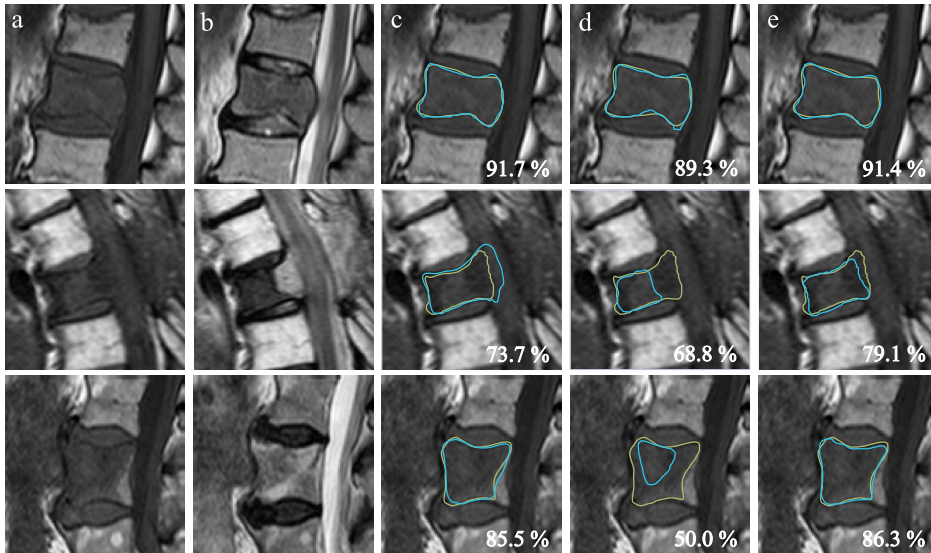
Comparison of expertly annotated data (green contours) and automatically produced segmentations (blue contours) using U-nets for three exemplary cases (rows). DSC scores in the lower right corners indicate the segmentation accuracy for each patient case w.r.t. the used MRI sequences. From left to right: (a) original T₁-weighted MRI sequence, (b) original T₂-weighted MRI sequence, (c) result with only T₁-weighted image data, (d) result with only T₂-weighted image data, (e) result with combined T₁- and T₂-weighted image data.
